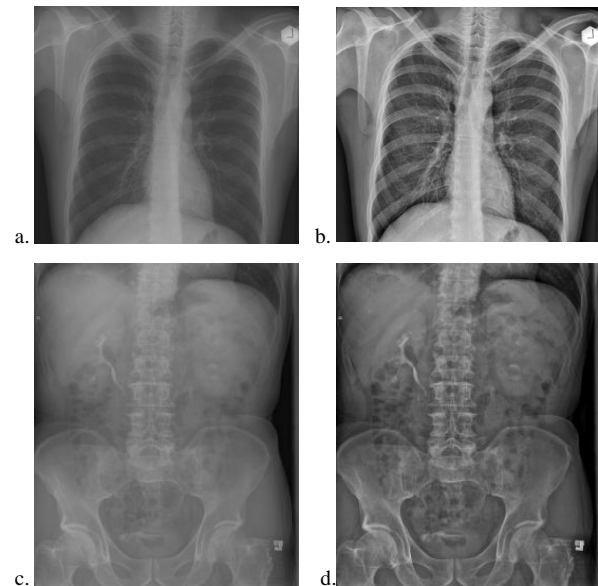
Examples of the necessity to use a post-processing of the images before they are used for diagnostic: a) image after capturing by incorrect apparatus settings; b) improvement of quality of image (1.a) with our method; c) image from digital X-ray apparatus, recorded in a file with 8 bits depth (JPG without compression); d) improvement of quality of image (1.c) with our method.
